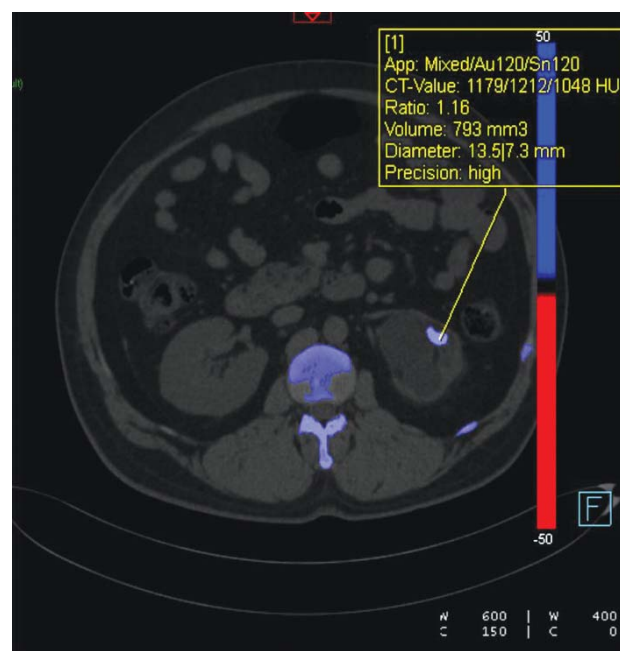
Stone density on NCCT using dual energy CT.
